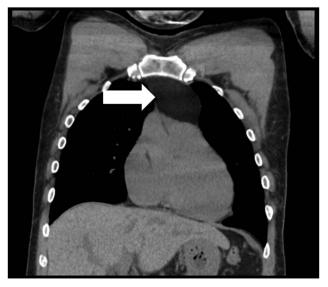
Thoracic computed tomography without contrast, coronal view. The arrow identifies a well-encapsulated large $7.5 \times 5 \times 6$ cm lipomatous anterosuperior mediastinal mass adjacent to the left phrenic nerve.
